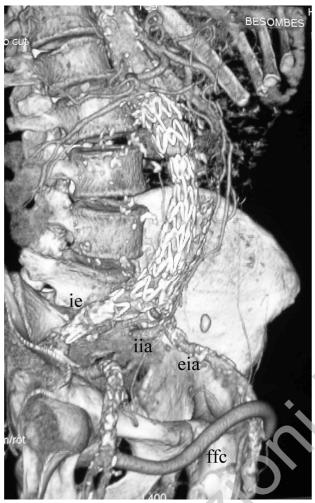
Control angio-CT with 3D reconstructions done six months later shows the correct positioning of the aortomonoliliac Talent™ endograft deployed inside the previously inserted aorto-biliac endoprosthesis and the iliac extension (ie) down to the right external iliac artery. No further endoleak is evident. The controlateral limb was occluded with a Medtronic's occluder. A right-to-left femoro-femoral crossover bypass graft (ffc) was fashioned in order to perfuse the left common femoral artery and the left internal iliac artery (iia) retrogradely by the left external iliac artery (eia).
